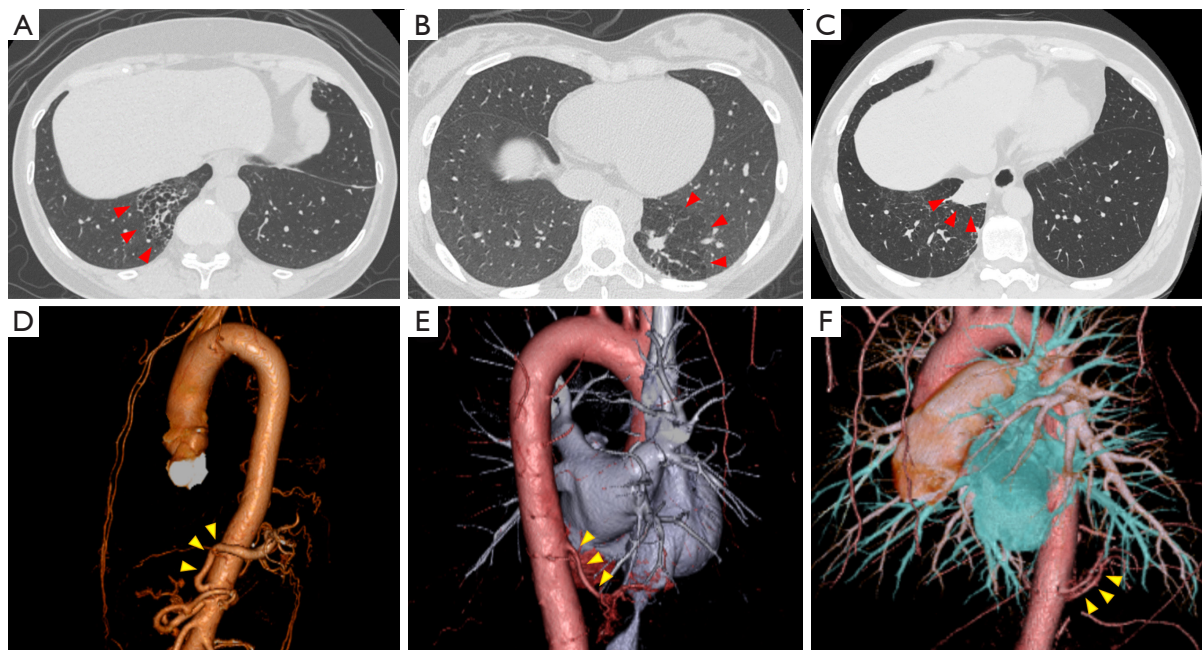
Preoperative computed tomographic images showing intralobar pulmonary sequestration with a mass and cystic lesions (red arrowheads) in cases 2 (A), 3 (B), and 6 (C). Reconstructed three-dimensional images showing the origin and running of aberrant arteries (yellow arrowheads) in cases 1 (D), 4 (E), and 5 (F).
